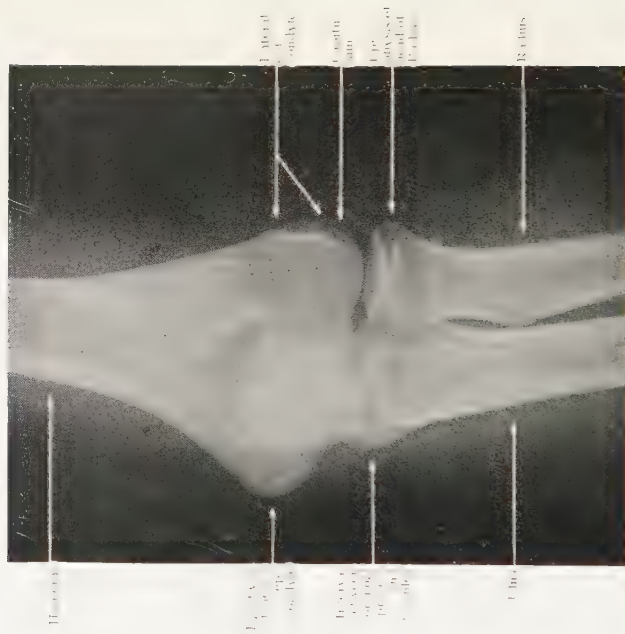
Radiograph of Elbow of girl aged 12, showing epiphyses of medial epicondyle of Humerus and head of Radius not yet united.
